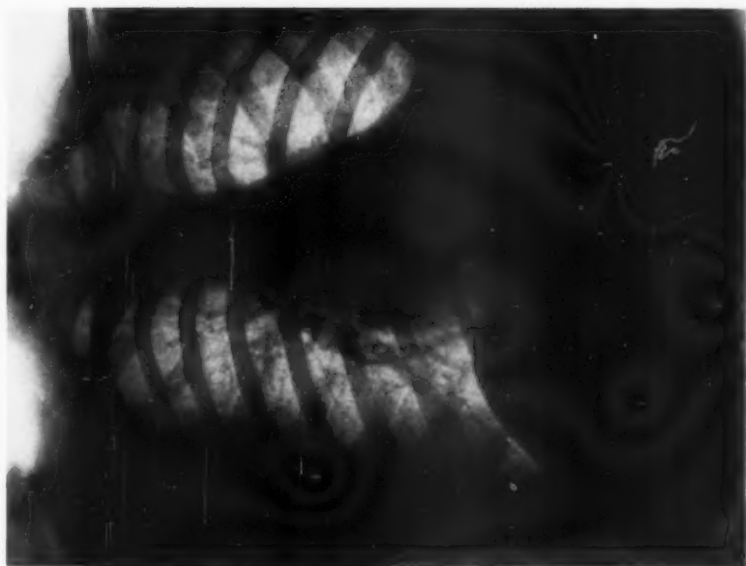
An ordinary radiograph.
